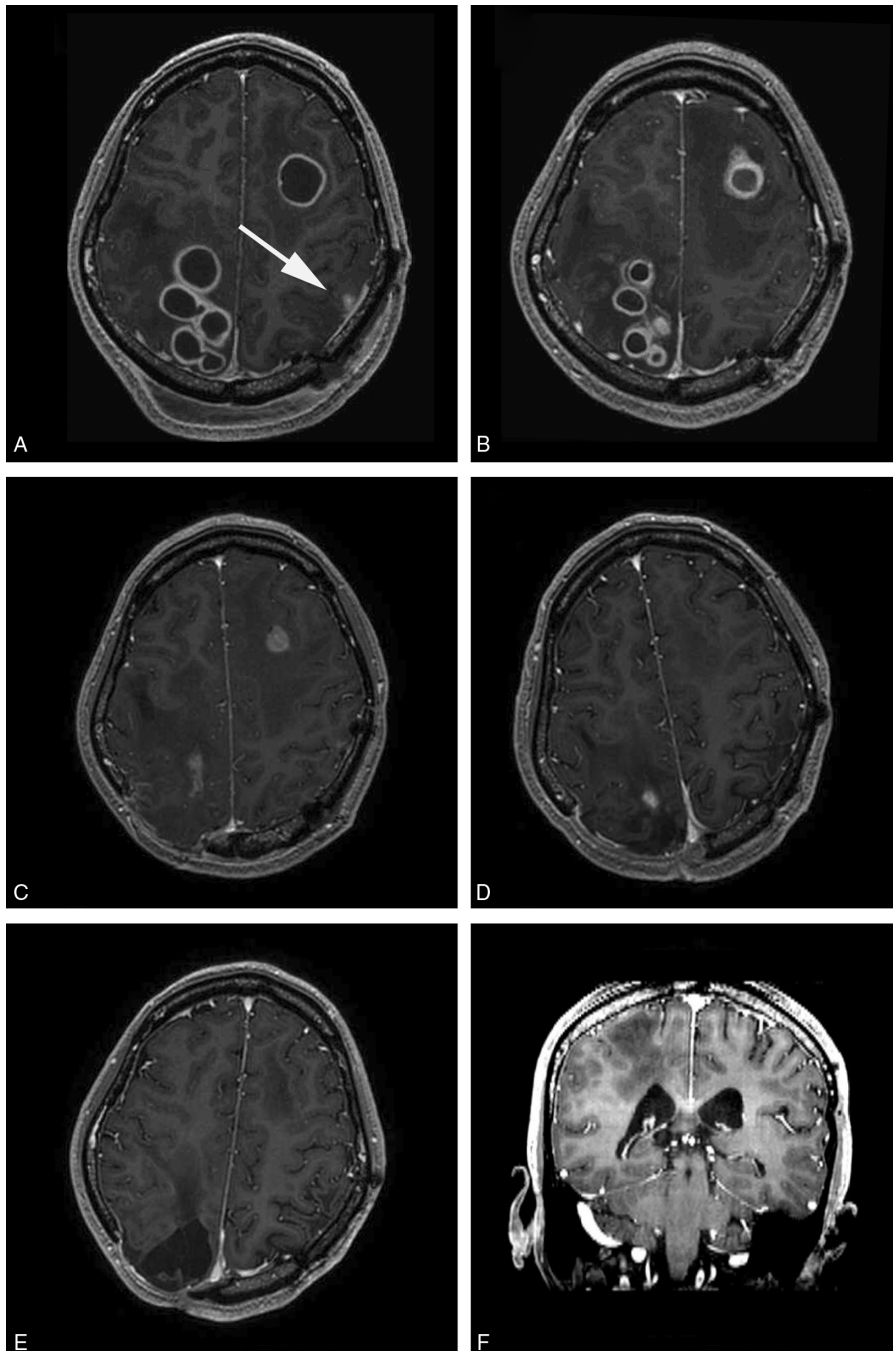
(A) T1-weighted contrast-enhanced image showed the lesion where stereotactic aspiration was done was obviously shrunk (arrow), other lesions were enlarged; (B) 4 weeks after linezolid used, the follow-up image showed the multifoci abscesses slightly shrunk; (C) 6-month follow-up image showed residual lesions on left frontal and right parietal lobe. (D) 12-month follow-up image showed a minor residual lesion on right parietal lobe. (E, F) Axial and coronal 30-month follow-up image did not demonstrate any enhancement of a residual mass.
